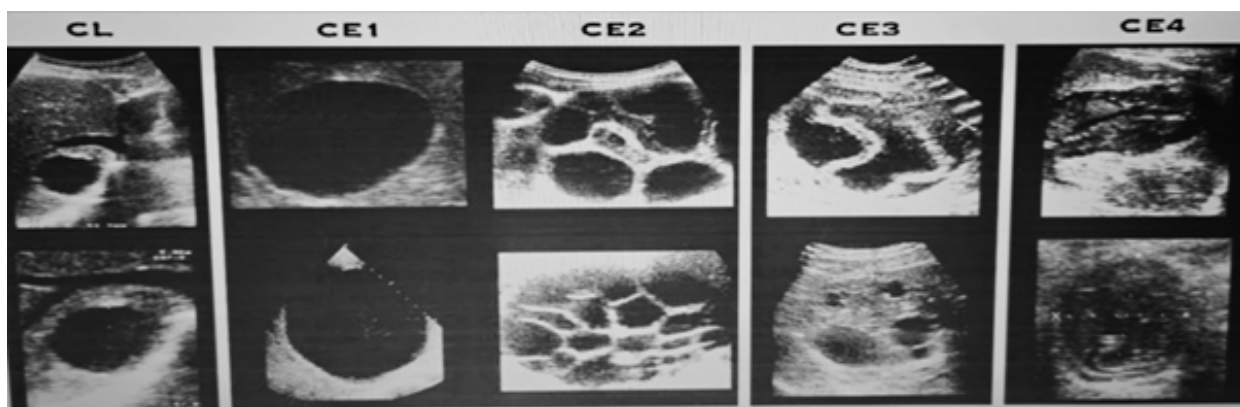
WHO Ultrasound Classification of the CE.
